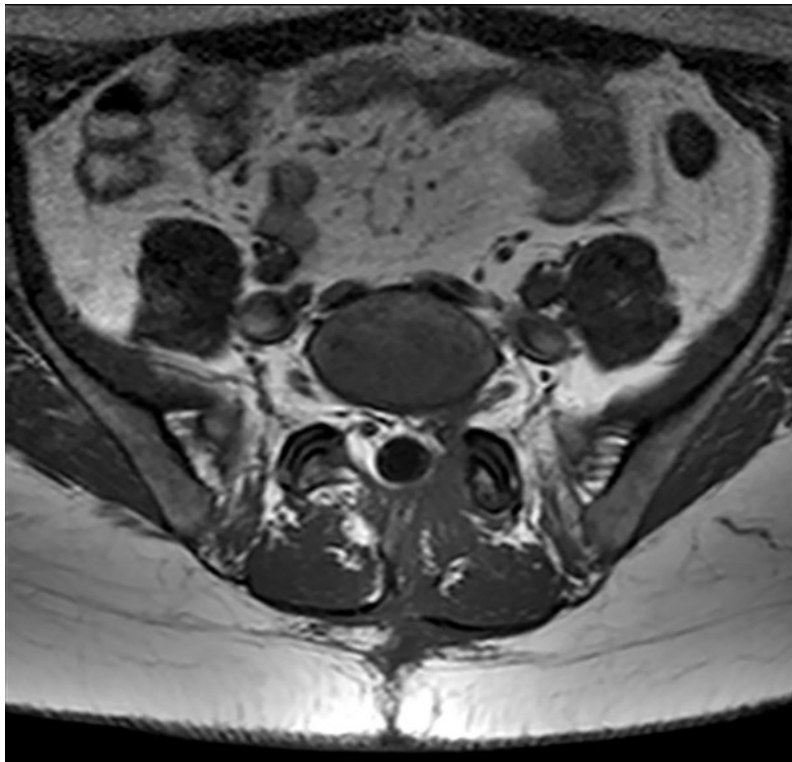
Pre and postoperative axial MRI demonstrate left L5-S1 facetectomy and complete cyst remotion.
